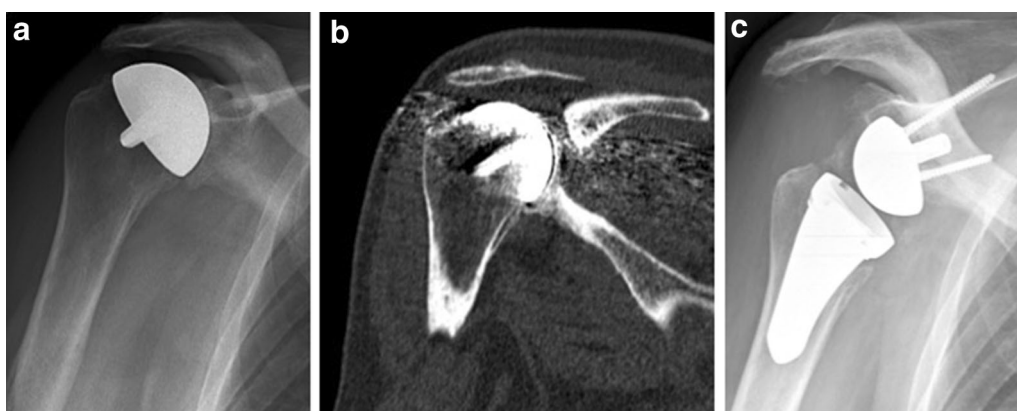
Glenoiditis in hemiarthroplasty. a Radiographic signs of glenoiditis in surface replacement hemiarthroplasty at 12 years of follow-up. b Pre-operative CT in glenoiditis. c Post-operative X-ray after revision with RSA
